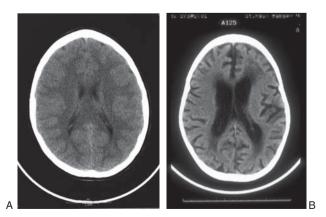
Cerebral atrophy. (A) Normal computed tomography (CT) scan. (B) CT scan showing posttraumatic brain injury cerebral atrophy with ventriculomegaly and increased sulci.
